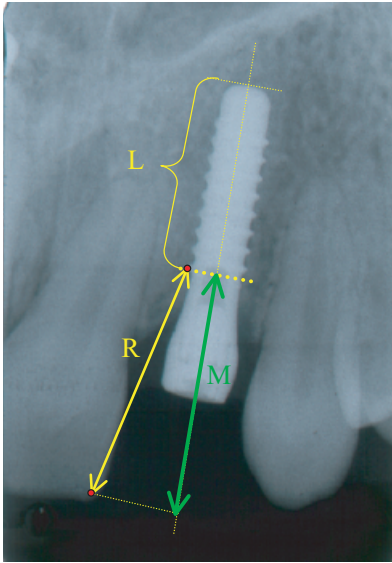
Assessment of the eruption of the adjacent teeth: (a) evaluation of the image distortion by measuring the length of the implant (= L) as it appears on the radiography compared to the real length of the implant; (b) selection of an easily identifiable point of reference (= •) located on the cervical thread of the implant; (c) selection of a point of reference located on the tooth adjacent to the implant (intersection point between incisal border and mesial or distal side of the tooth); (d) measurement of the distance (= R) between the projection of the two selected points on the longitudinal axis of the implant (T0); (e) measurement, on the radiograph taken at the follow-up examination (T1), of the distance between the projection of the two selected points on the longitudinal axis of the implant (= M); and (f) measurement of the amount of vertical movement of the adjacent tooth, by comparing the data obtained at T0 and T1.
